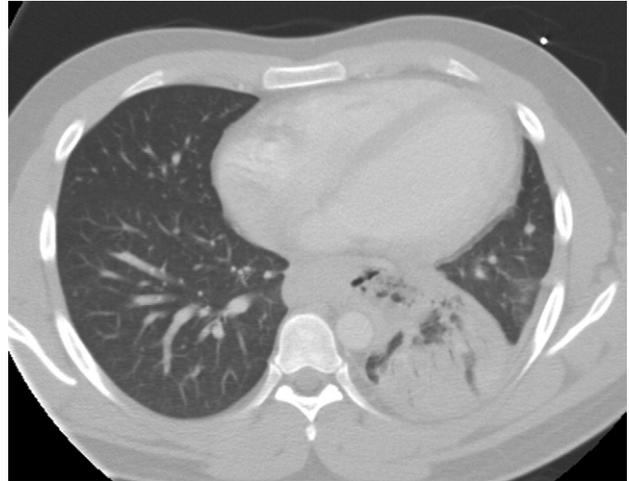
A chest computed tomography scan of patient 1 shows left lower lobe destruction and upper lobe preservation.
